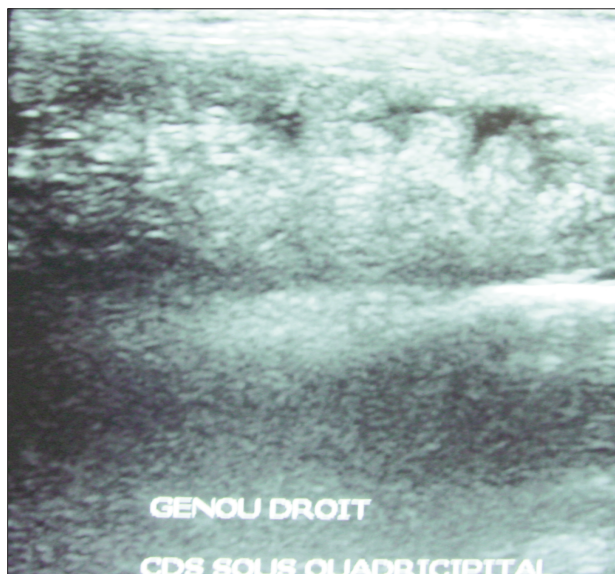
Ultrasonography transversal scan of the knee : homogeneous hyperechoic irregular
